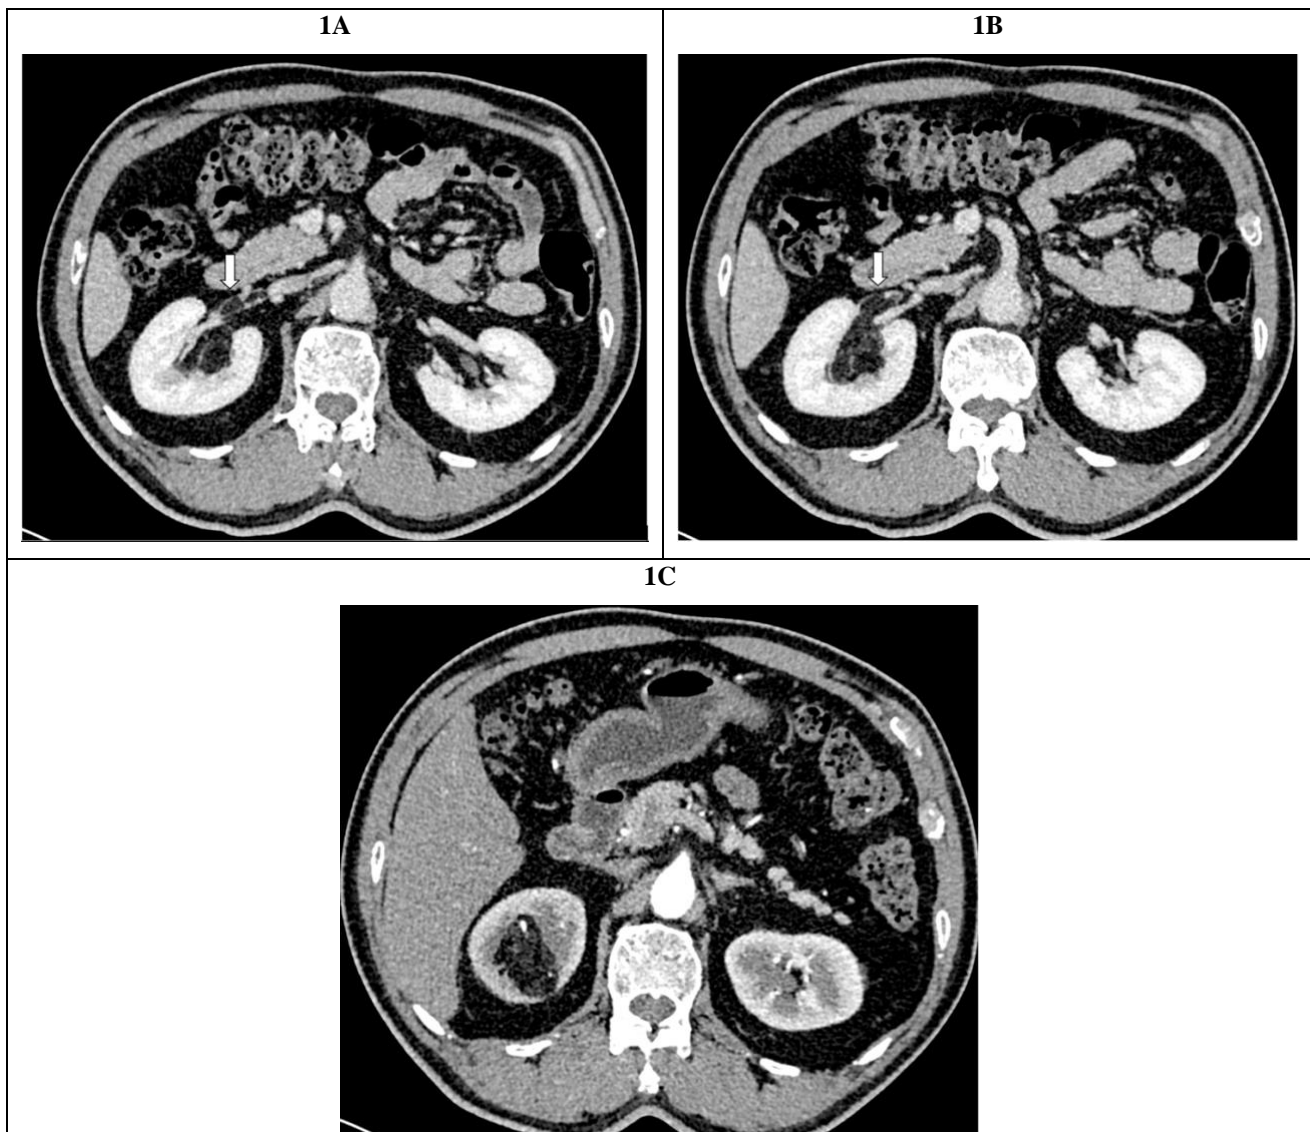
Contrast-enhancing axial CT images (Figure 1A-1C) show a renal mass at upper pole of right kidney containing fat attenuation with fatty tumour thrombus (arrow) invasion into right renal vein.
